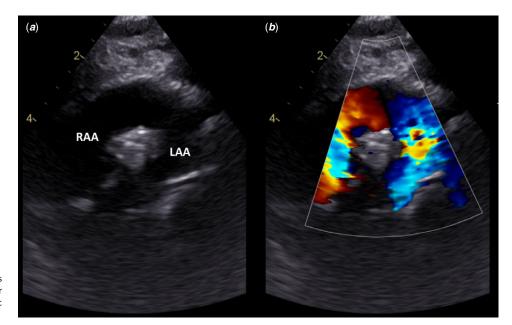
Suprasternal short axis echocardiogram view in 2D (a) and colour Doppler (b). LAA: left aortic arch; RAA: right aortic arch.
